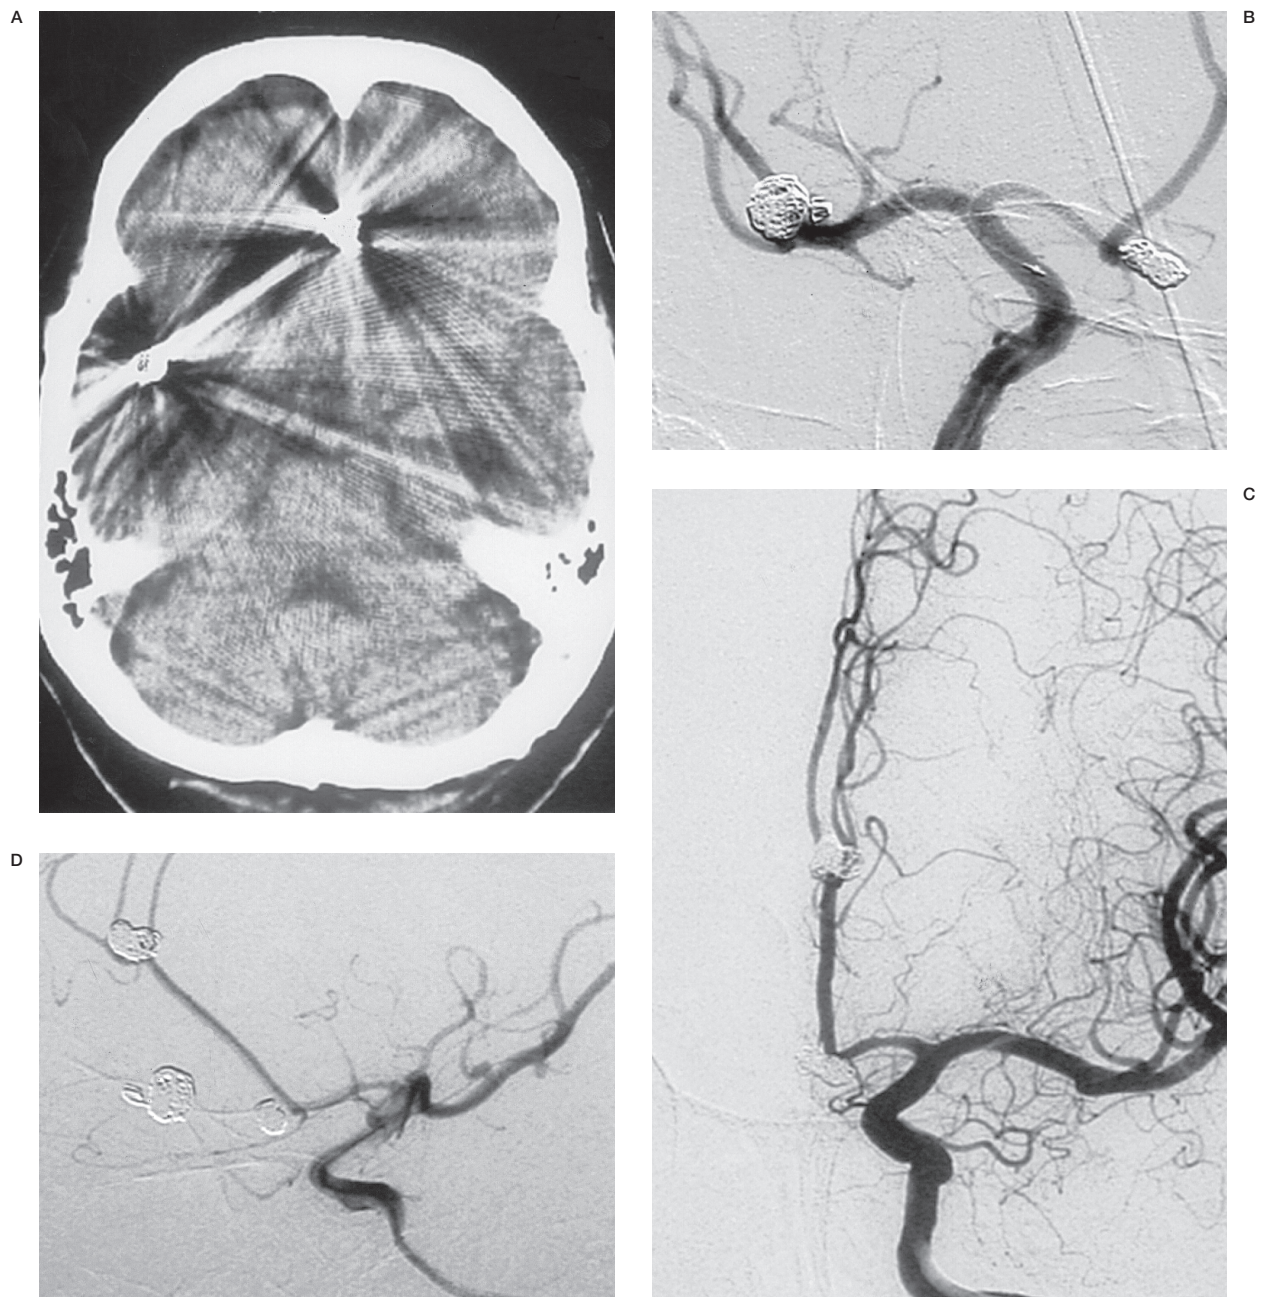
Postoperative radiological findings. A) Brain computed tomography showing coil artifact. B) Right internal carotid oblique angiography showing occlusion of two middle cerebral artery aneurysms and an anterior communicating artery aneurysm. C) Left anteroposterior internal carotid angiography showing occlusion of a left A2 aneurysm. D) Left lateral internal carotid angiography showing occlusion of two right middle cerebral artery aneurysms, anterior communicating artery aneurysm and left A2 aneurysm.
